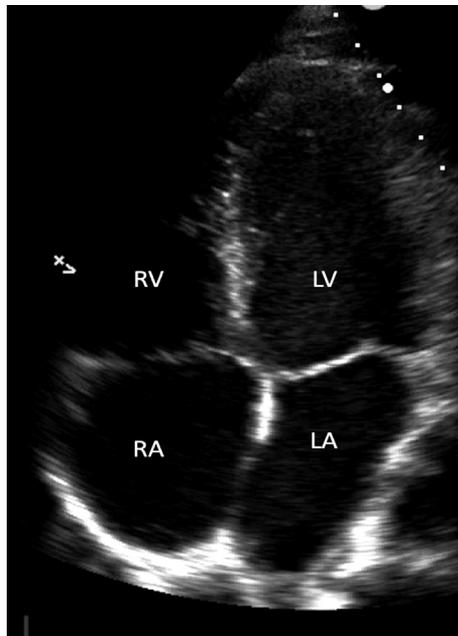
Apical four chamber view. RV: right ventricle, LV: left ventricle, RA: right atrium, LA: left atrium.
